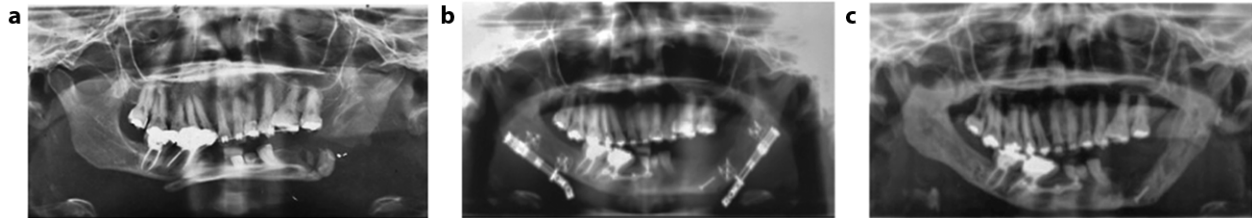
Panoramic radiographs (a) Initial radiography taken in 2012; (b) Radiography with bilateral mandibular distractors; (c) radiography taken at the end of the mandibular free graft bone distraction.
